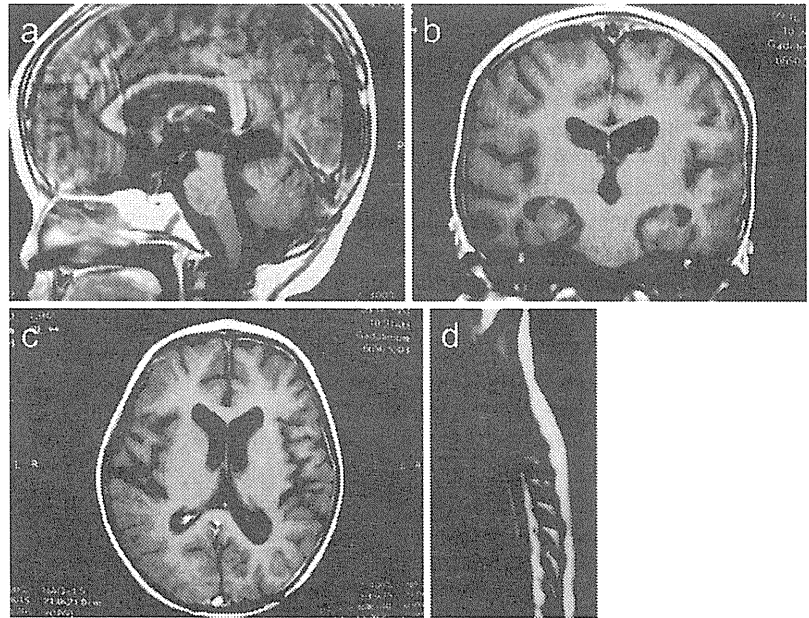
The disseminated tumors disappeared after the first autologous PBSCT. Sagittal (a), coronal (b), axial (c), and sagittal spinal (d) gadolinium-enhanced T1-weighted magnetic resonance images are shown
